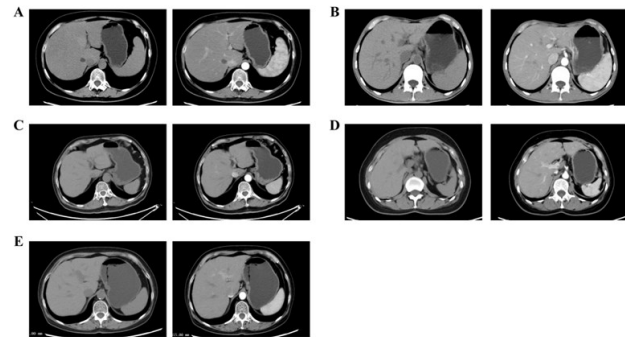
CT plain images of some patients before and after the use of contrast agents. (A) Female, 57 years old, neuroendocrine tumor. (B) Male, 41 years old, outpatient, nasopharyngeal carcinoma malignant tumor. (C) Male, 70 years old, malignant tumor of descending colon. (D) Female, 55 years old, lung cancer of the upper lobe of the left lung. (E) F, 63 y/o, malignant tumor of rectum.
